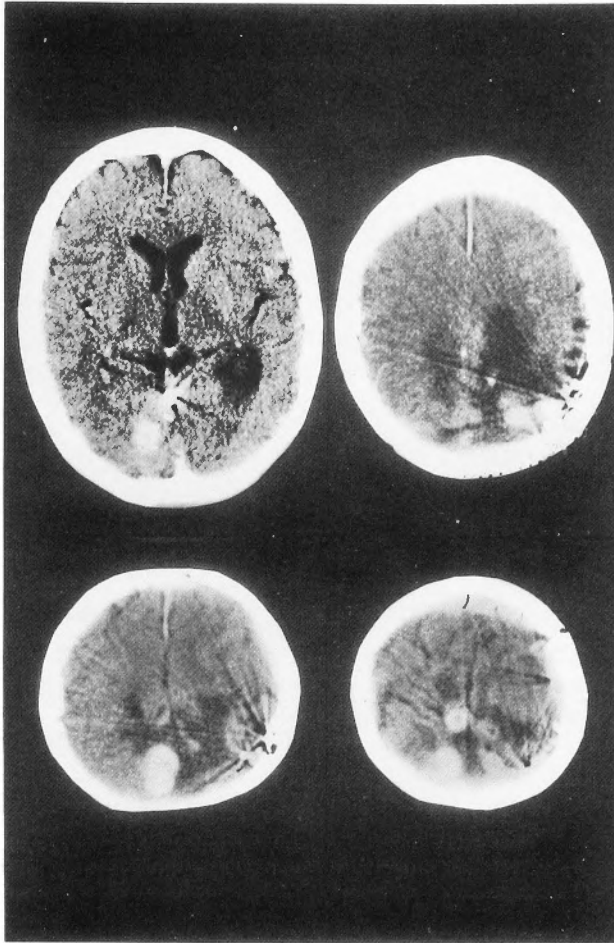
Enhanced CT before the sixth operation. Multiple tumors are seen in the tentorium and the occipital convexity and parietal falx.
